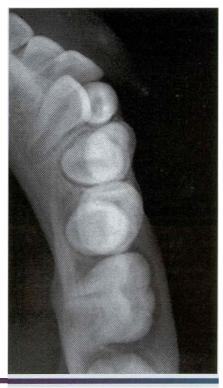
Buccal bifurcation cyst. Occlusal radiograph of the lesion shown in Figure 15-45. Note the lingual displacement of the roots of the first permanent molar. (Courtesy of Dr. Michael Pharoah.)
